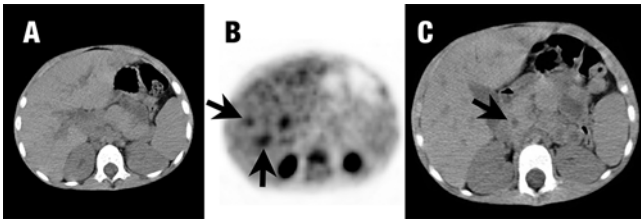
^{18}F -FDG PET/CT (A,B, C) demonstrated ^{18}F -FDG accumulation in biliary tract (A, B) and dilatation in ductus choledochus (C) (arrows).
